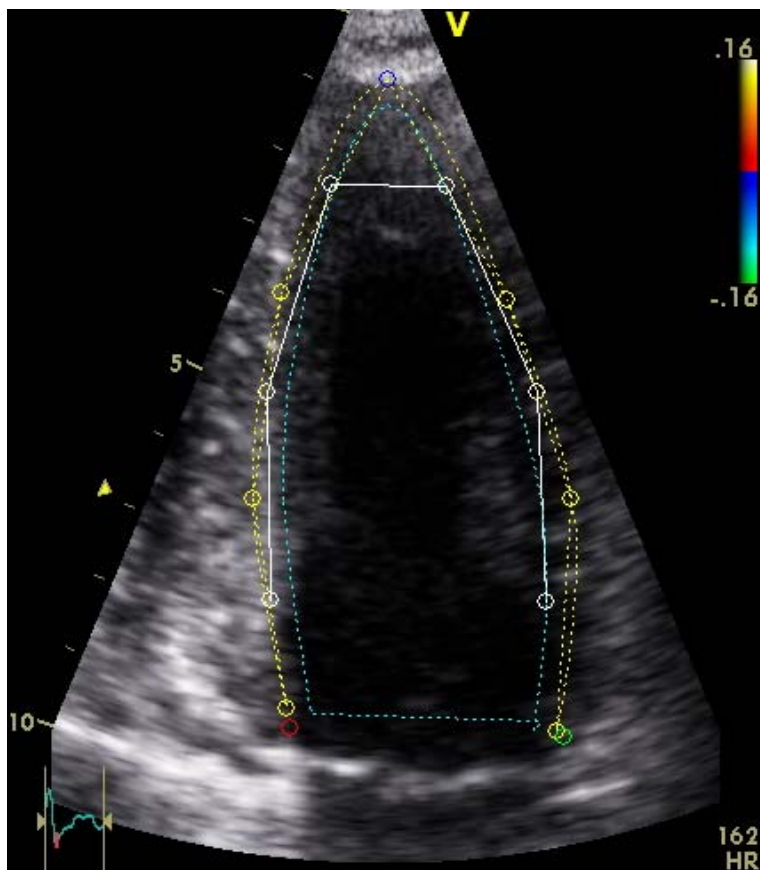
An automated system using TDI for tracking along the ultrasound beam and speckle tracking perpendicular to the ultrasound beam. In this apical four-chamber view from a healthy subject undergoing dobutamine stress echocardiography at peak stress, the left ventricle has been divided automatically into six segments, divided by yellow points. The white points represent the middle of each segment.
